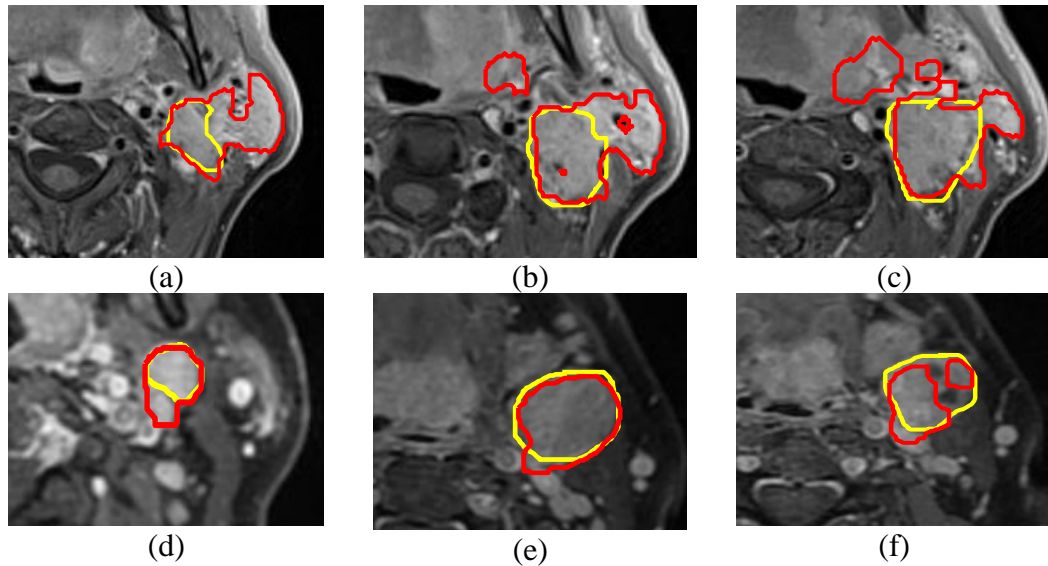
Examples of T1 axial MRI slices with ALNs drawn by manual (yellow) and automatic algorithm (red). (a-c) are from first patient. (d-f) are from second patient
